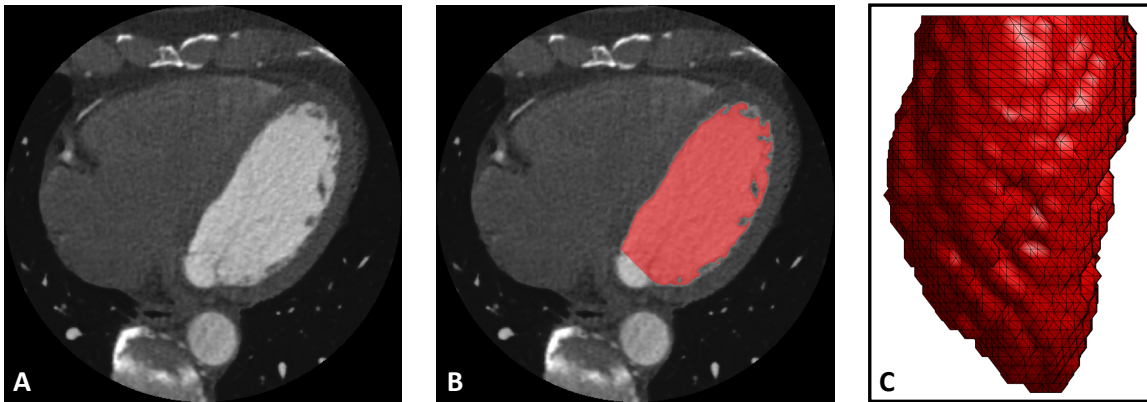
Image segmentation and mesh extraction. (A) Axial slice of the CT image. (B) Axial slice with the LV blood volume segmentation overlaid in red (with the mitral valve and the LV outflow-tract defined as the cut-off points). (C) 3D rendering of the extracted LV endocardial mesh, looking at the lateral wall with the anterior wall to the left, and the inferior wall to the right.
